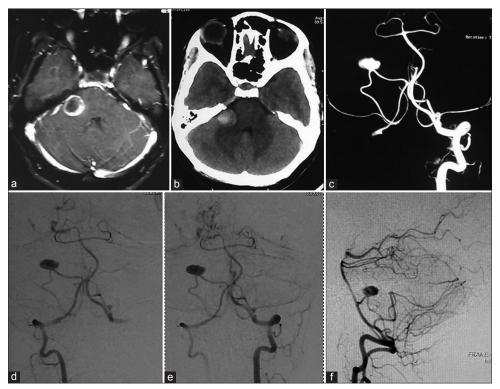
Preoperative images (a) gadolinium enhanced magnetic resonance image of brain; (b) plane computer tomography scan brain showing cerebellopontine angle mass lesion, vertebral angiogram; (c) three-dimensional reconstructed image; (d and e) posterior view; (f) lateral view
